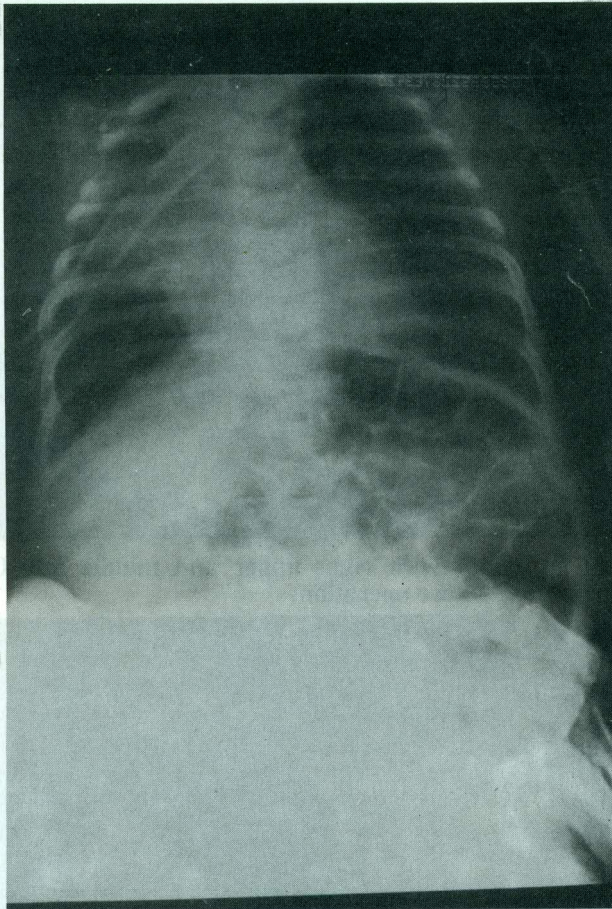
Summated CT scan of right upper and middle lobe Congenital cystic adenomatoid malformation of the same child. In fig 4, before operation.
